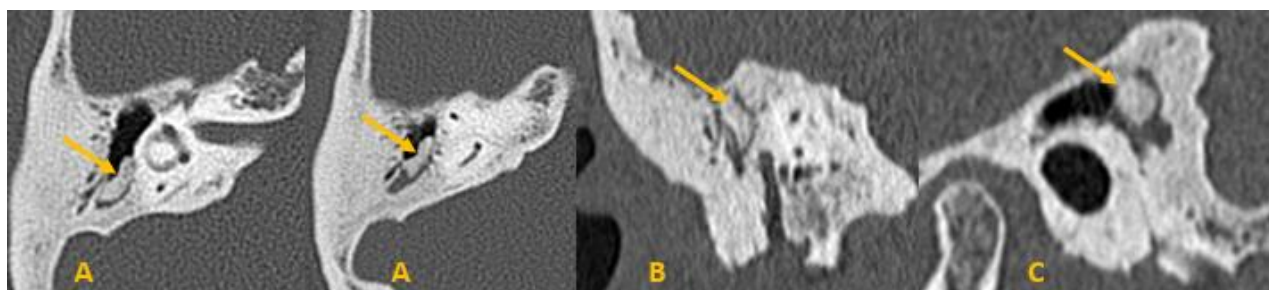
High resolution CT of the temporal bone in axial (A), coronal (B) and sagittal (C) sections, showing a rounded, bone density mass (arrow) occupying the meso tympanum and the antrum and hanging to the tegmen antri
